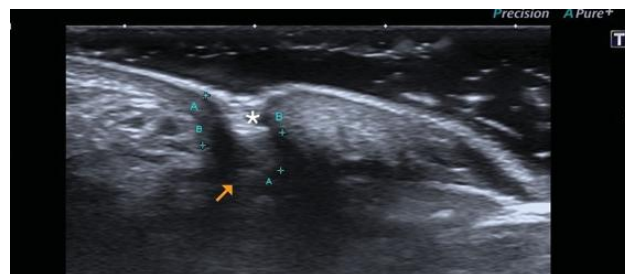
High-resolution longitudinal ultrasound image with an 18 MHz linear transducer, demonstrates a well-defined, hyperechoic (white asterisk) linear structure delimited by a markedly hypoechoic band with well-defined edges corresponding to the constricting band, (yellow arrow) covering the three layers of skin without bone compromise. Between calipers A + the length of the band is demonstrated, calipers B + show the thickness of the band
